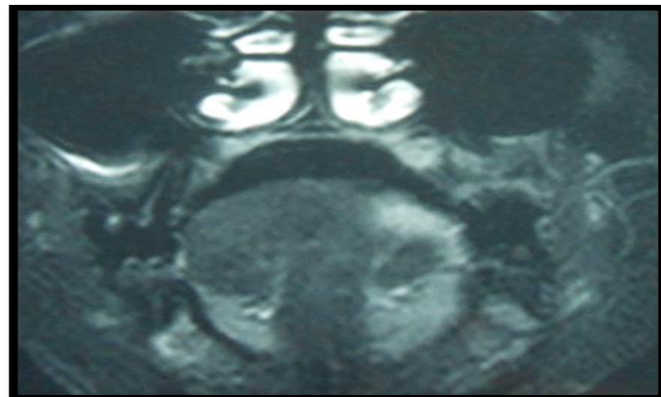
MRI image revealed a focal ulceration along the left border of the tongue with hyper intense signal on T2/T2-SPIR images
